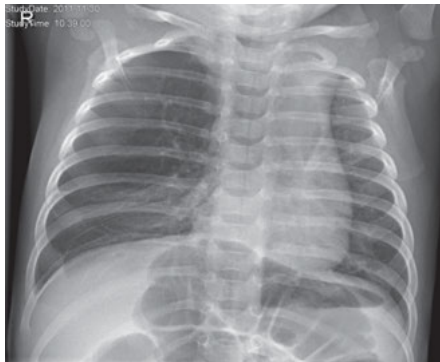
Chest X-ray of a 3-month-old boy with congenital lobar emphysema of the right upper lobe. The malformation compressed the surrounding lung tissue and caused a shift of the mediastinum to the left, and the boy presented early with respiratory distress.
